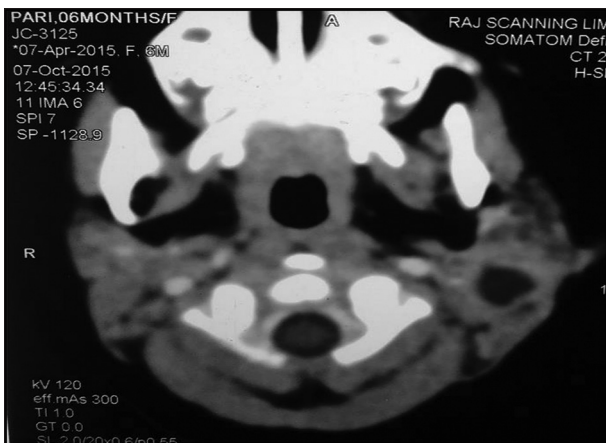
Computed tomography scan axial section showing cystic lesion
